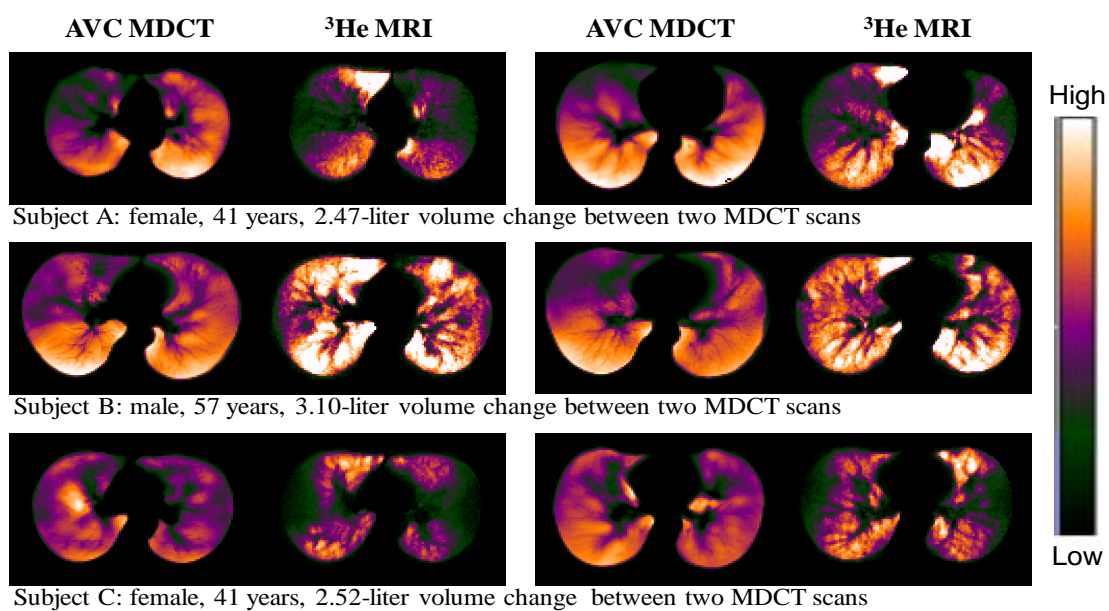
Comparisons between MRI-based ^3He distribution and MDCT-based AVC map for three subjects. Two transverse sections are shown for each subject.
